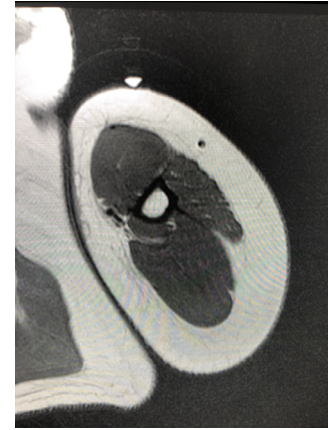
Pre-operative MRI, axial plane, of the upper arm. The implant was unable to be discriminated from other anatomic landmarks.
